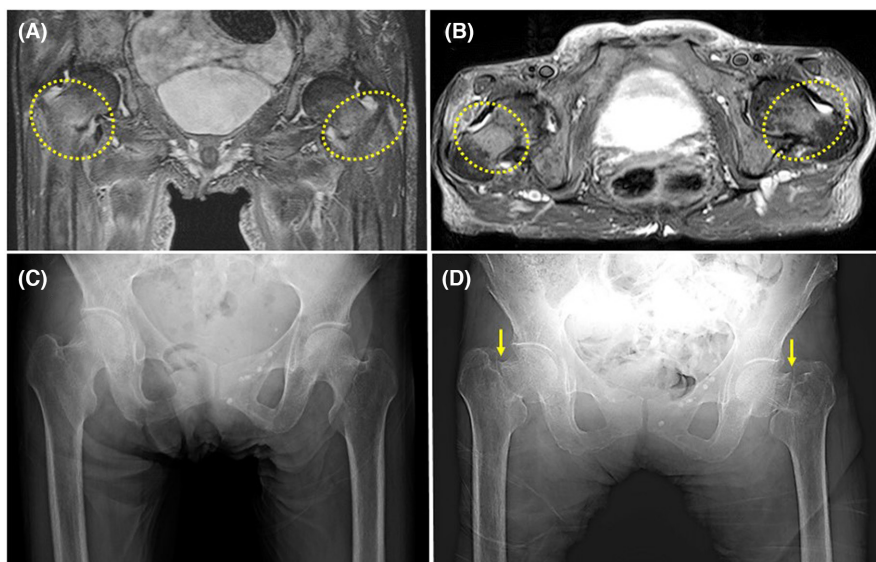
Image findings at patient's first and second visit. At the patient's first visit; (A, B) T2-weighted magnetic resonance images showed a slight bilateral signal change in the proximal femur with no clear fracture line (yellow dot circles); (C) no Looser's zone in both femoral necks and no obvious abnormalities on X-rays. At patient's second visit; (D) an X-ray 1 month after the initial examination showed a bilateral basicervical femoral neck fractures with displacement (yellow arrows).
